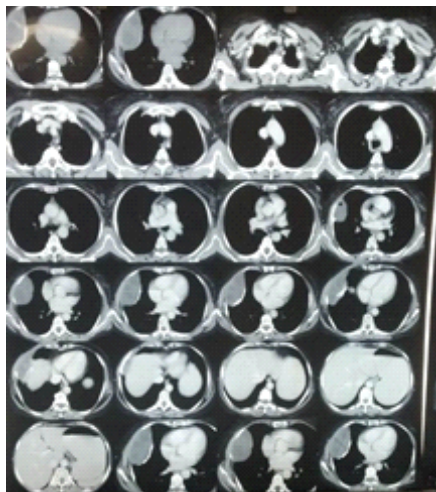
HRCT of the pulmonary hydatid cyst with cystocutaneous fistula
